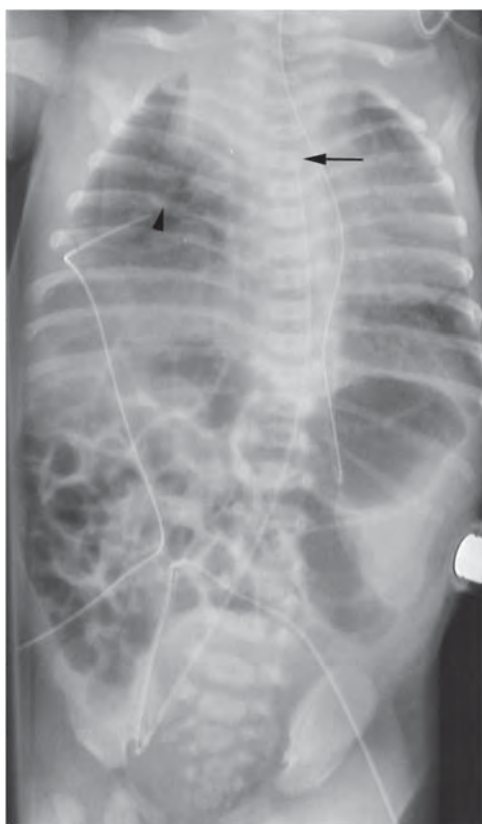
X-ray of a newborn with persistent right umbilical vein. The catheter in the umbilical artery courses in a normal fashion via the right iliac artery up into the descending aorta with the tip at the level of Th3 (arrow). Catheter inserted in the umbilical vein goes towards the right costophrenic angle and turns with the tip in a medial direction (arrowhead). Source: Nikstad and Smevik 2004 [22]. Copyright © 2004 Nakstad and Smevik. Reprinted with permission.
